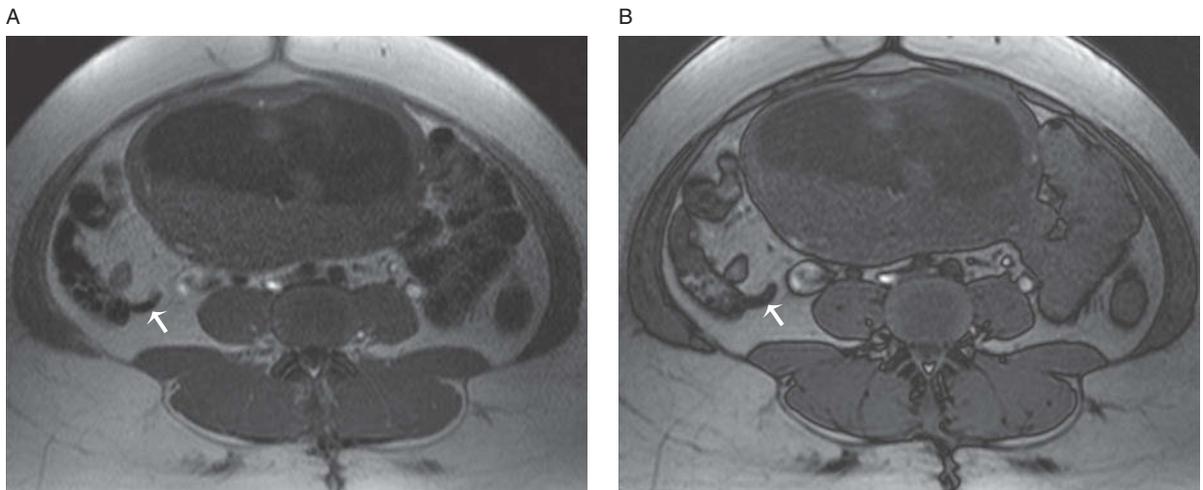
Normal appendix in a 26-year-old pregnant female. Axial T1-weighted image in phase (A) also demonstrates the normal-caliber appendix (arrow) as well as decreased luminal signal intensity on the in-phase image compared to the out-of-phase (B) image due to blooming artifact from air in the appendix, further supporting the diagnosis of a normal, non-obstructed appendix.
